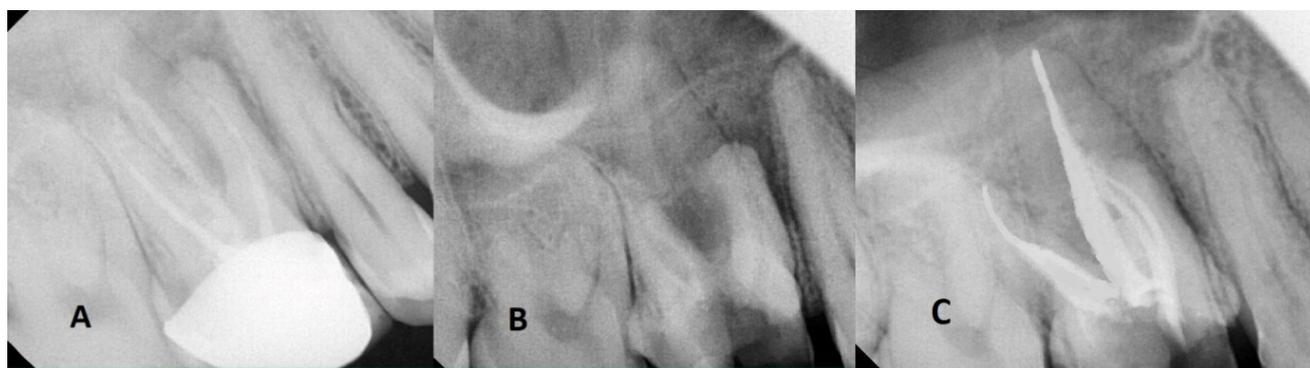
Case 4: A): Preoperative radiographic image; B): Gutta percha removal from canals; C): Post obturation
